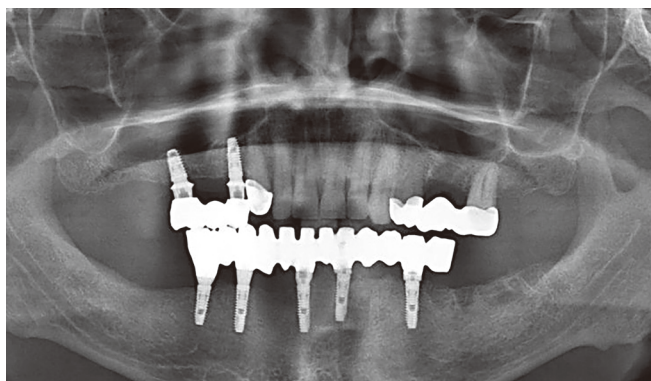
X-ray control immediately after the fixation of a permanent denture.
